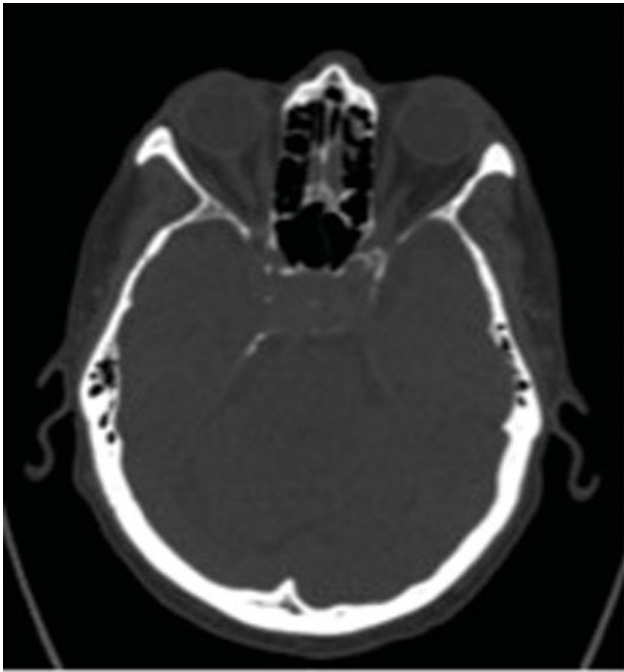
Noncontrast enhanced CT at the level of the pituitary gland shows a $2.5 \times 3.5 \times 3.9$ cm midline skull base mass involving the sella and suprasella.
